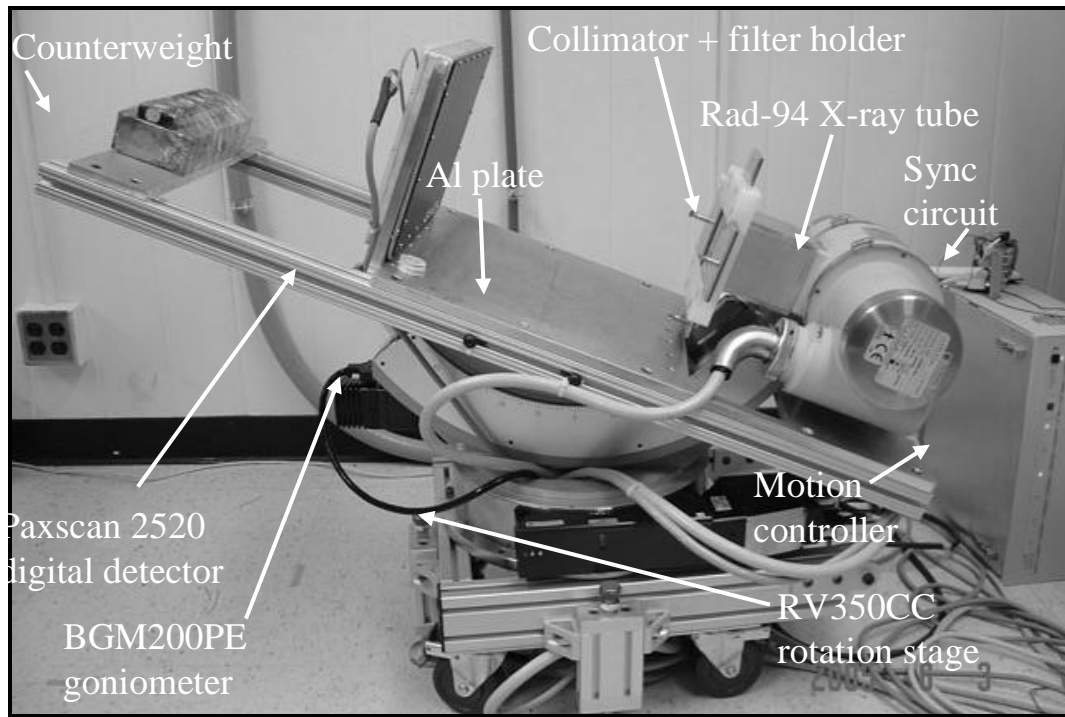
System setup denoting components that have been integrated in a functioning prototype. Components include the BGM200PE goniometer and RV350CC rotation stage, the Varian Rad-94 tungsten X-ray tube and Varian Paxscan 2520 digital X-ray detector, the Al mounting plate, and the synchronization circuit.
